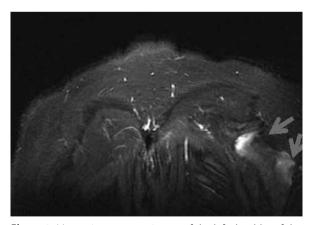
Magnetic resonance image of the left shoulder of the reported case. Coronal view on STIR (short-time inversion recovery). The STIR-weighted image showing a high-intensity signal in the infraspinatus muscle (arrows) suggests a denervation lesion. This finding is frequently reported in neuralgic amyotrophic patients, although it is not very specific.
